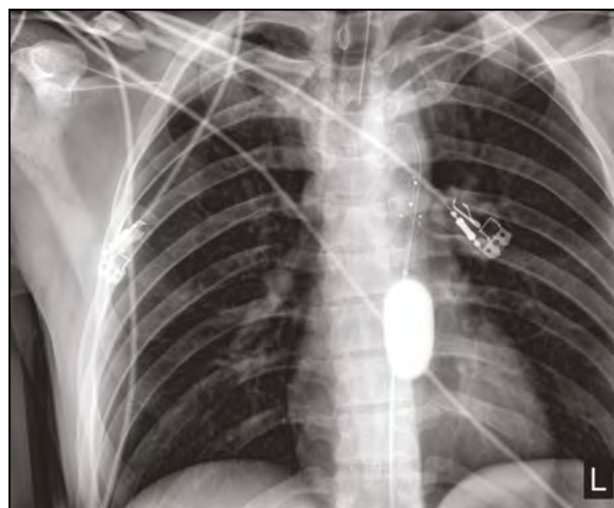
REBOA in the second wounded patient. An X-ray image confirming the correct position of the balloon in the descending thoracic aorta. The balloon is filled with a mixture of a radiopaque medium and normal saline. The balloon used was manufactured by the Limited Liability Company "Minimally Invasive Technologies" with a built-in guidewire
